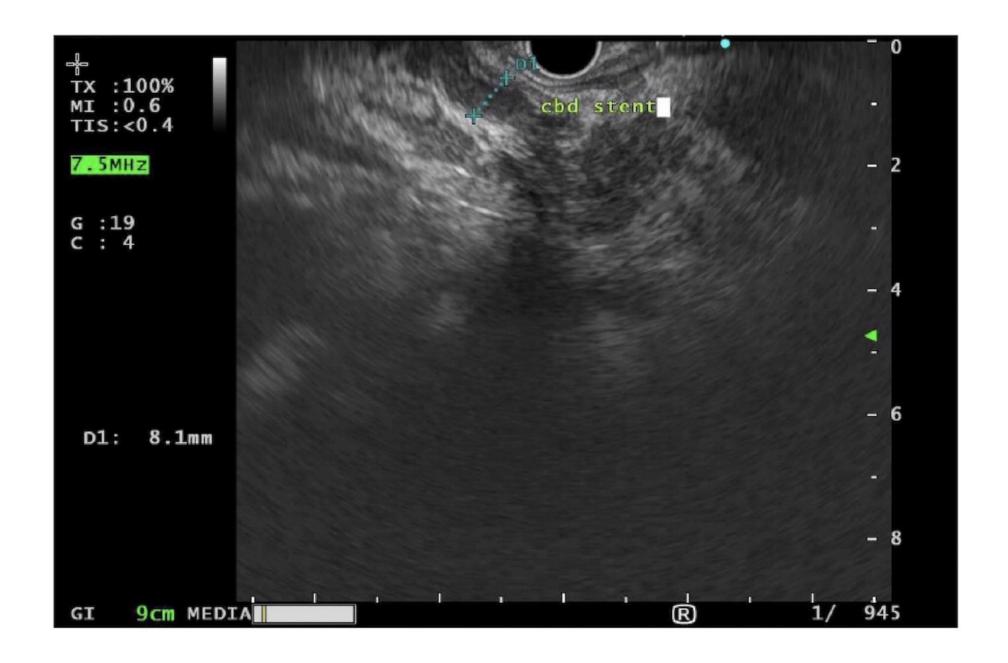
a) CT showing inflammatory reaction of the pancreas with bile duct dilation; b) Bile duct stricture on ERCP; c) EUS image showing common bile duct stent
